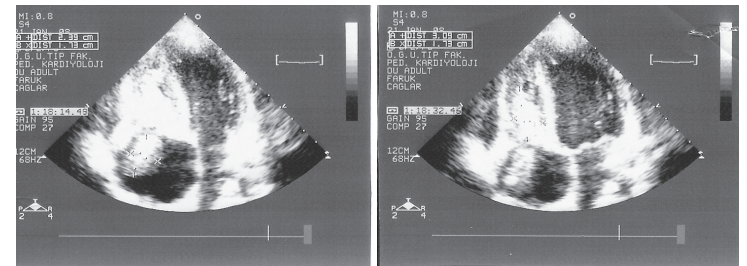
Echocardiographic view of the thrombi in the right atrium.
